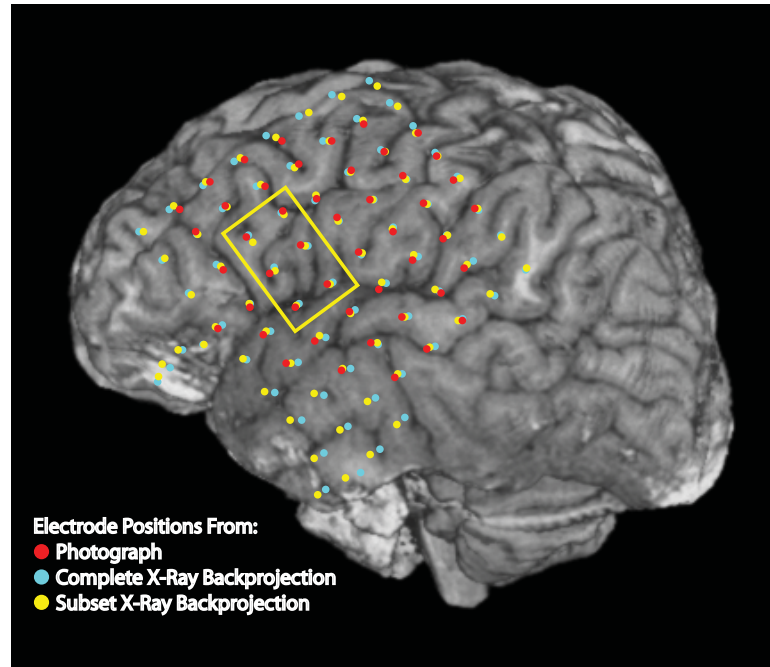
Evaluation of registration for the same patient shown in Figure 4.1. Known electrode positions from the photograph are shown as red dots, and the results from using the projective transform with all known electrode positions are depicted in blue. Since it is not possible to validate the location of hidden electrodes, a subset of six visible electrodes (boxed in yellow) were chosen to compute another projective transform. This transform was then applied to all X-ray locations, with the backprojection solution shown in yellow. The results from just these six electrodes agree closely with the known photograph-based positions as well as the results from the complete projective transform.
